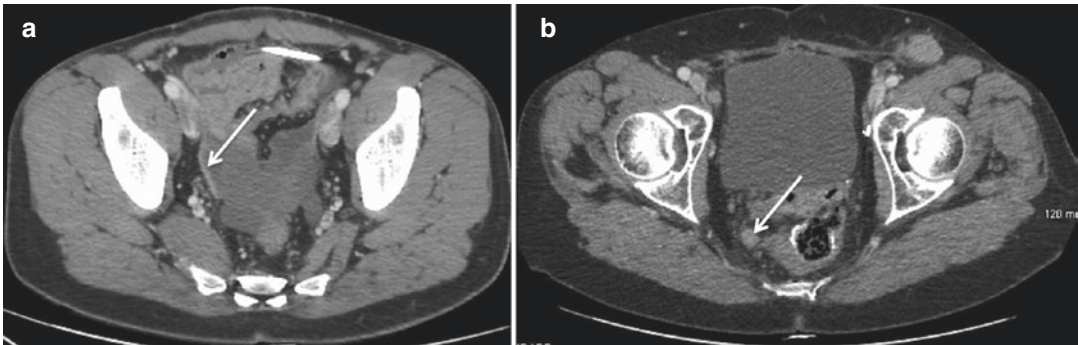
Axial contrast CT showing thickening of the Douglas pouch (a) and soft tissue nodule on the mesorectal fascia (b)
